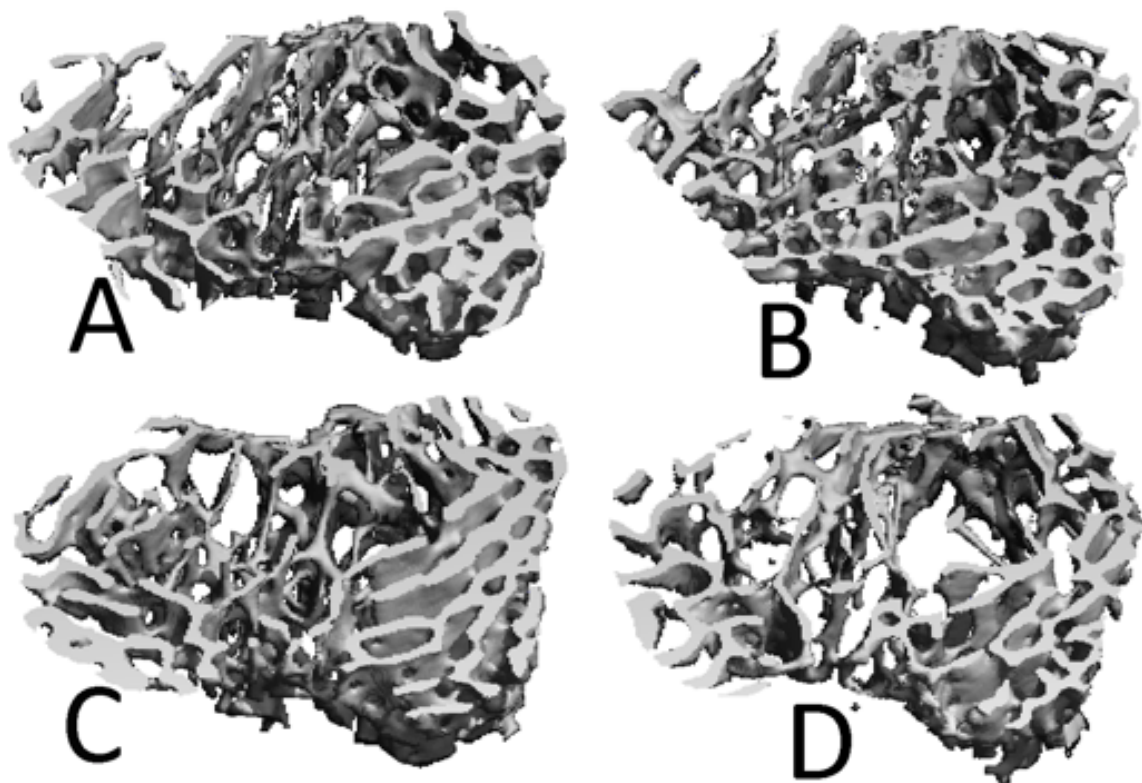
Representative 3D images of trabecular bone from the proximal tibia μ CT scans. A: C57 Sham; B: C57 5/6Nx; C: FVB Sham; D: FVB 5/6Nx
